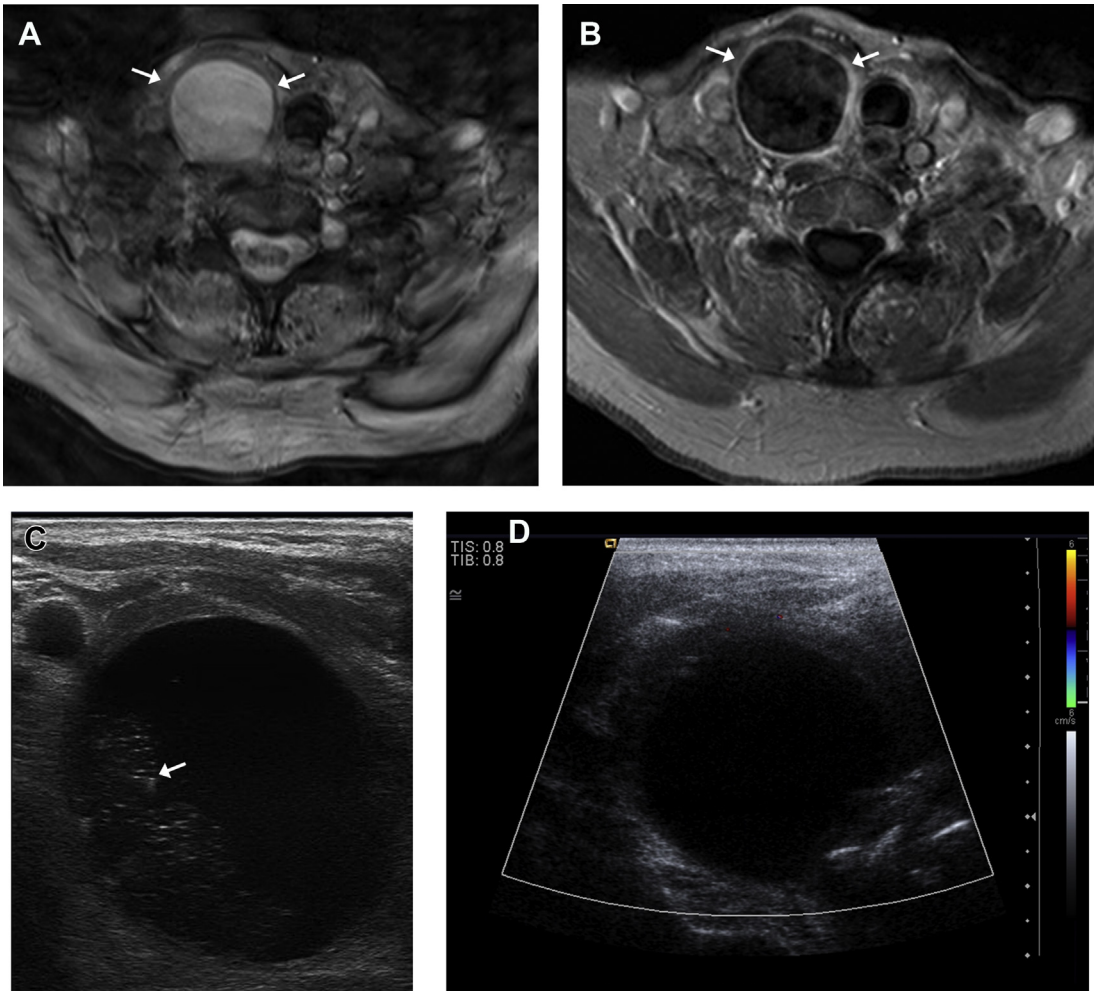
Axial T2-weighted (A) and postcontrast T1-weighted (B) MR images show a rounded nonenhancing T2-hyperintense lesion (arrows) in the right thyroid lobe. Grayscale (C) and color Doppler (D) US images show an anechoic cyst lacking vascular flow and containing echogenic foci that have comet-tail artifacts (arrow) and likely represent colloid inclusions. This is considered benign by both ATA and ACR TI-RADS criteria.
